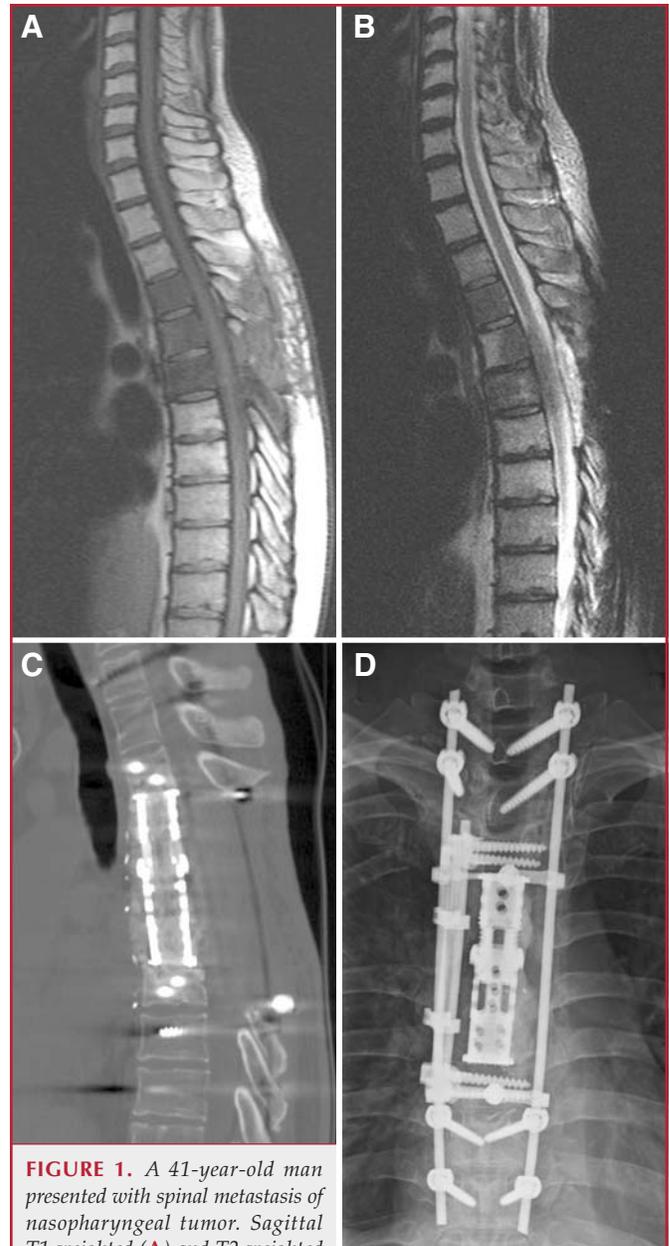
A 41-year-old man presented with spinal metastasis of nasopharyngeal tumor. Sagittal T1-weighted (A) and T2-weighted (B) magnetic resonance imaging scans showing metastasis from T4 to T6 extending posteriorly. Transthoracic 3-level corpectomy with implantation of VLIFT (Stryker, Kalamazoo, MI) and additional anterior fixation at T3 to T7 was performed. Second-stage posterior surgery included resection of posterior elements at T4 to T6, and pedicle screw fixation at T1 to T9. Postoperative sagittal computed tomography (C) and anteroposterior x-ray (D) showing solid fusion with stable circumferential construction.
